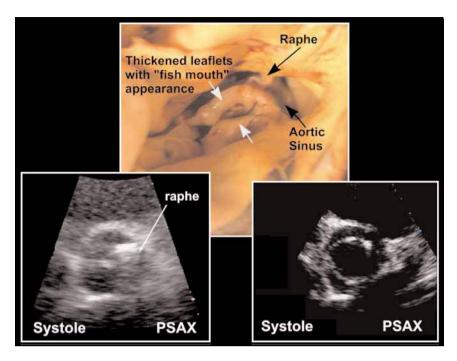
Bicuspid aortic valves may have a visible raphe—the fusion ridge of two aortic leaflets. The aortic orifice often exhibits an ovoid or "fish mouth" appearance during systole. PSAX, parasternal short axis view. (Please *see* companion DVD for corresponding video.)
